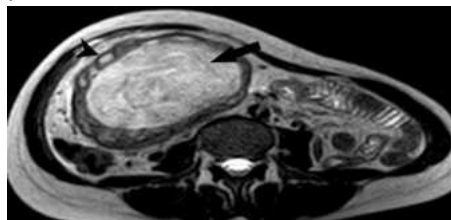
MRI Axial T2W image shows thick wall well encapsulated lesion with small hyperintense lesions in the periphery mimicking daughter cysts (arrowhead) and fine hypointensities within mimicking hydatid membranes representing the wavy pattern of the gauge (arrow)
